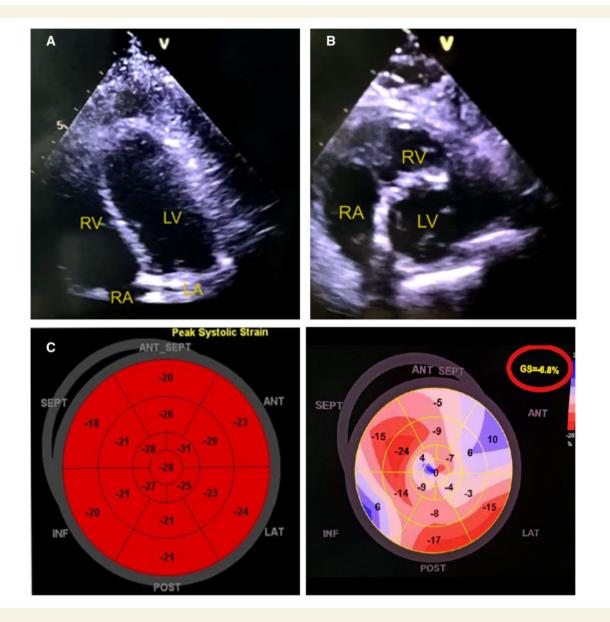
Representative transthoracic echocardiography frames (selected from cine loop images) from a patient with COVID-19. (A) Apical four-chamber view showing globally reduced left ventricular contraction, especially in the apical segment. The right ventricle is dilated and an echo-free space, indicating pericardial effusion, is present. (B) Parasternal short axis view showing markedly reduced left ventricular contraction, enlarged right ventricle, and a mural thrombosis in the right ventricle outflow tract. (C) Two-dimensional speckle tracking echocardiography based on speckle tracking imaging technology (2D STE). Left panel showing a normal 2D STE, right showing a 2D STE from a patient with COVID-19 and myocarditis, depicting reduced regional peak systolic strain rates. Data were collected as part of a retrospective study, Wuhan, China; consent was waived and collection of these data was approved by the local ethics committee. Kindly provided by Professor Dao Wen Wang.
